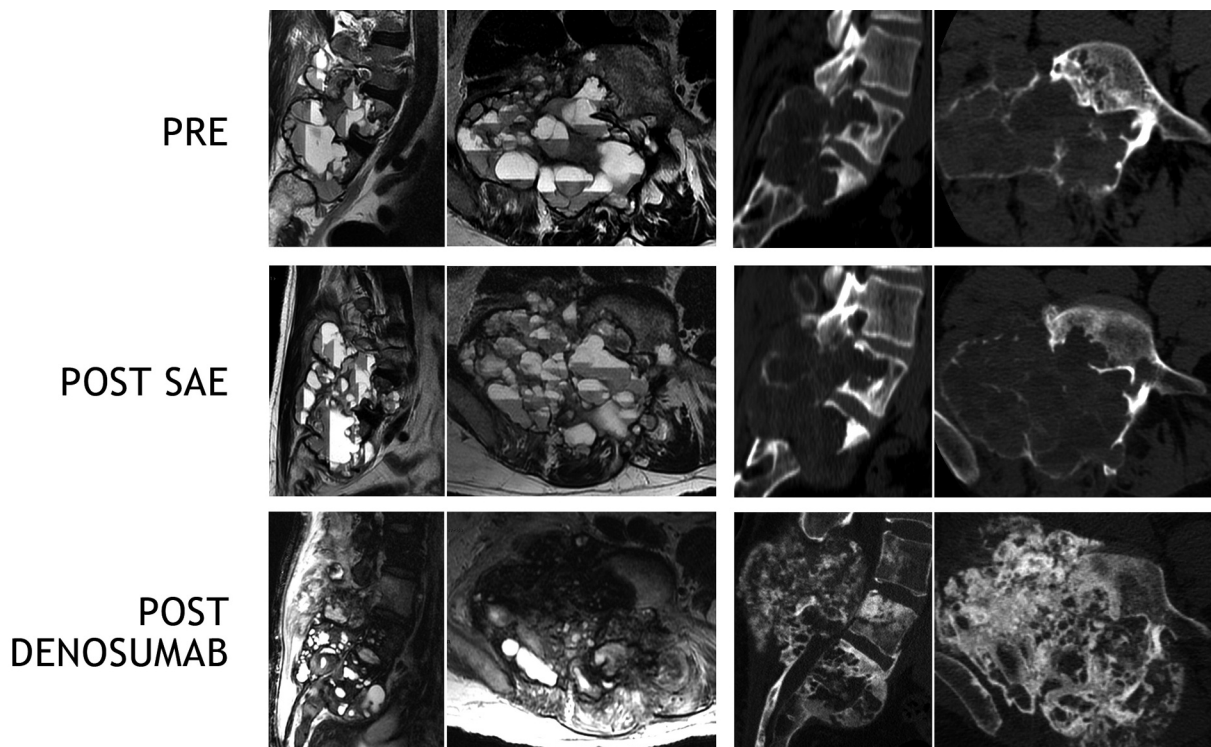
Imaging history of Case 1, reporting CT scan and MRI performed before ABC treatment, after embolization and after treatment with Denosumab.
